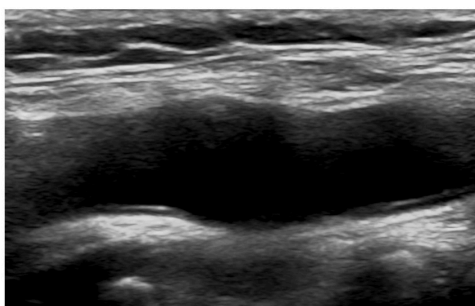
Mr. DC's Carotid Doppler showing a patent carotid artery with no signs of stenosis or atherosclerotic plaque
